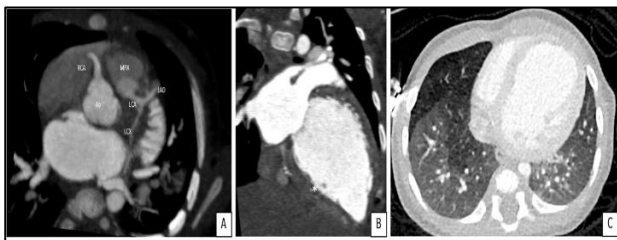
(A-C): Oblique axial MPR image showing LCA arising from posterior sinus of main pulmonary artery and right coronary artery (RCA) arising from right coronary sinus of aorta. Oblique MPR CT image showing dilation of left ventricle and left atrium with decreased enhancement in subendocardial aspect of left ventricular wall (*). Axial CT image in lung window-shows mosaic attenuation in bilateral lower lobes of lungs.
